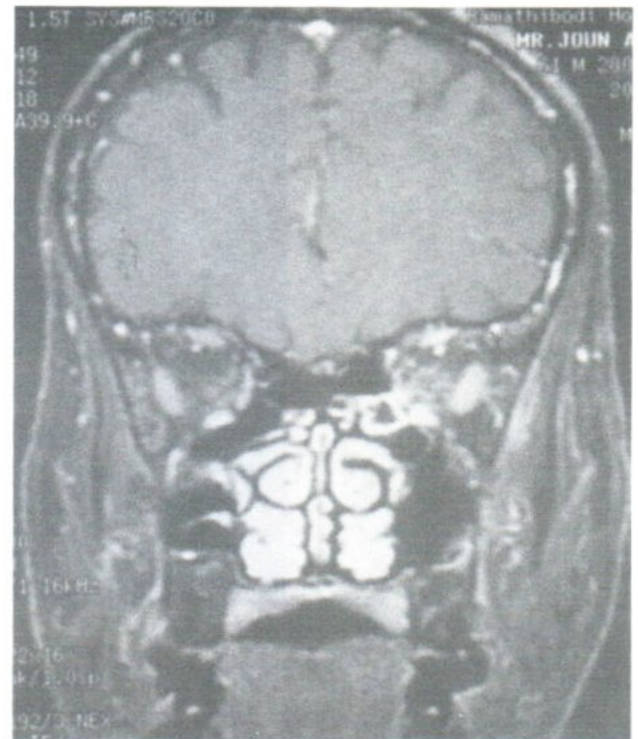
I.V. enhanced coronal MRI of the orbits showed mild ethmoidal sinusitis.
